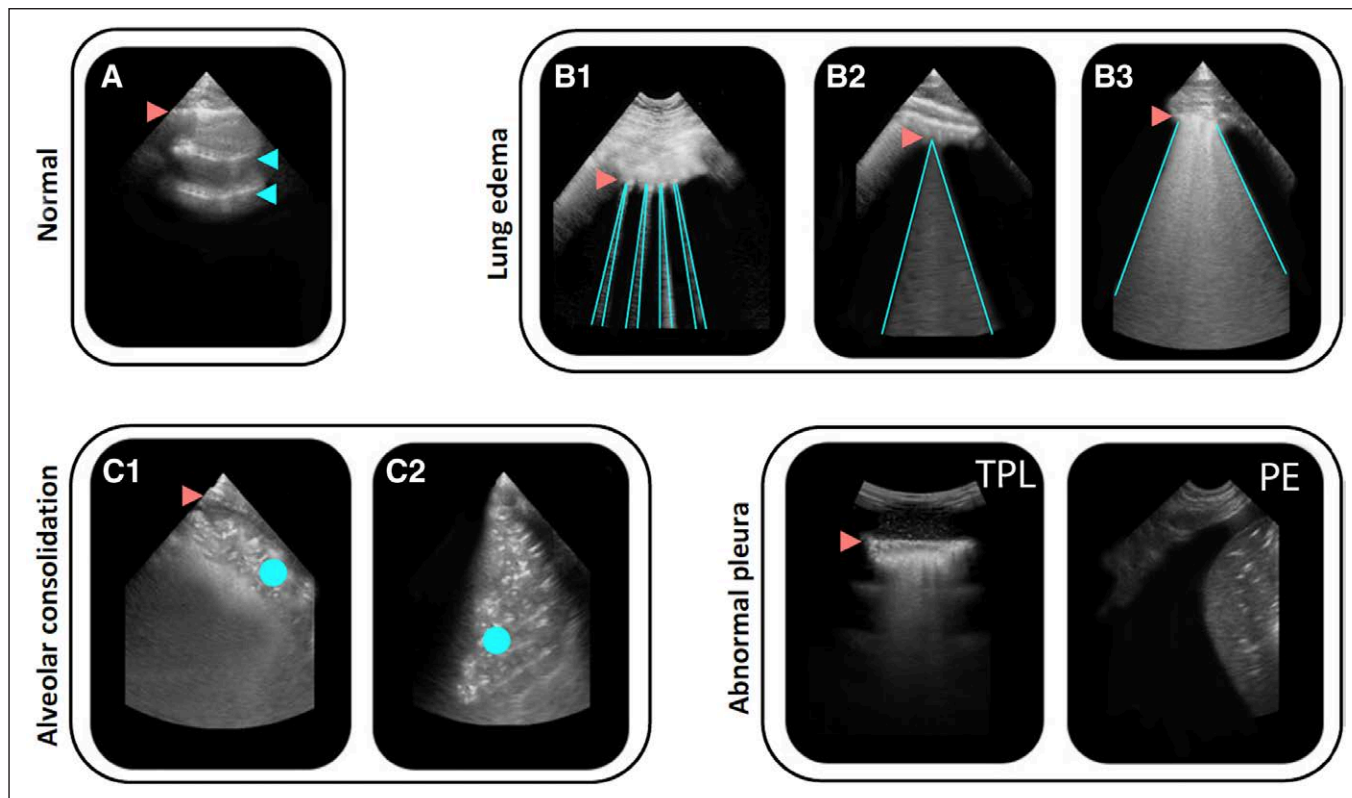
Lung ultrasound patterns. Each of the 12 lung regions assessed per patient was classified using predefined lung ultrasounds profiles (A, B1, B2, B3, C1, C2, TPL, and pleural effusion [PE]). Sonographic LUS signs are not specific of COVID-19 when considered alone. Normal lung sliding (*magenta triangles* indicate the pleural line) with *reverberating horizontal lines* (blue triangles) were described as a profile. Interstitial syndrome was defined as the presence of more than two vertical lines in a given lung sector (depicted between *vertical blue lines*). To allow a semiquantitative assessment, we defined three B-lines patterns: B1 profile (thin, multiple, and well-defined), B2 profile (large and coalescent), and B3 profile (“shining white lung”). As recently reported, we distinguished two patterns of alveolar consolidation (*blue circles*): subpleural nontranslobar (C1 profile) (27) and posterior translobar with occasional mobile air bronchograms (C2 profile). A thickening of the pleural line with pleural line irregularity was considered as abnormal (Thickening of the Pleural Line, TPL), and PE was defined as a hypoechoic collection limited by the diaphragm and the pleura (PE profile). For additional information regarding lung ultrasounds semiotics, please see the “Materials and Methods” section.
